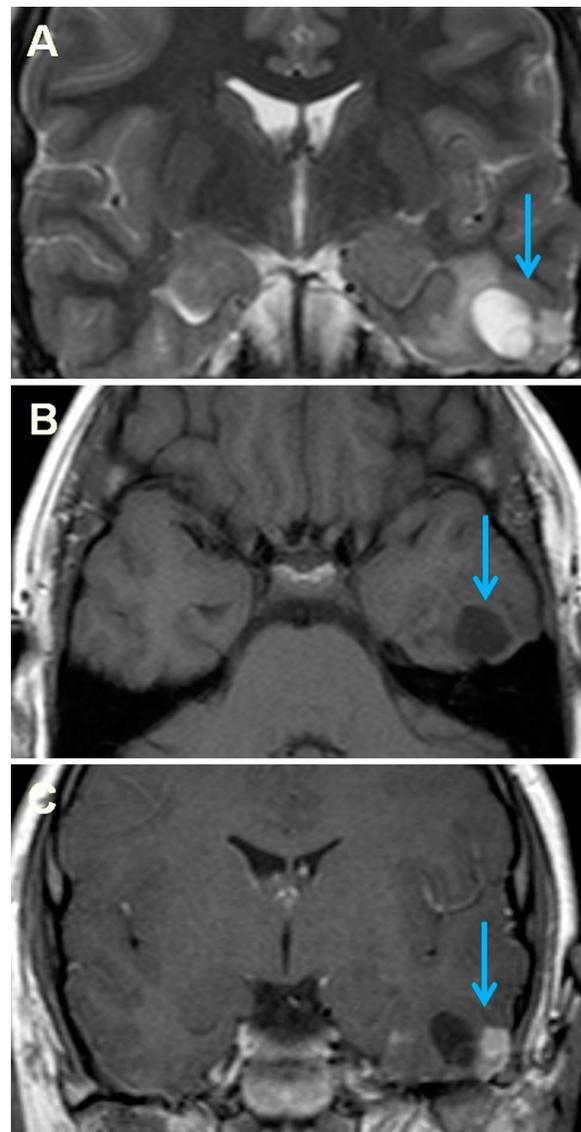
ST GG in a 13 year old boy with seizures. a T2-weighted coronal image shows a well-circumscribed hyperintense left temporal lobe mass with adjacent edema. b T1-weighted axial image shows a hypointense mass. c T1-weighted post contrast coronal image shows heterogeneous enhancement with both solid and cystic components (mass marked by blue arrows)
